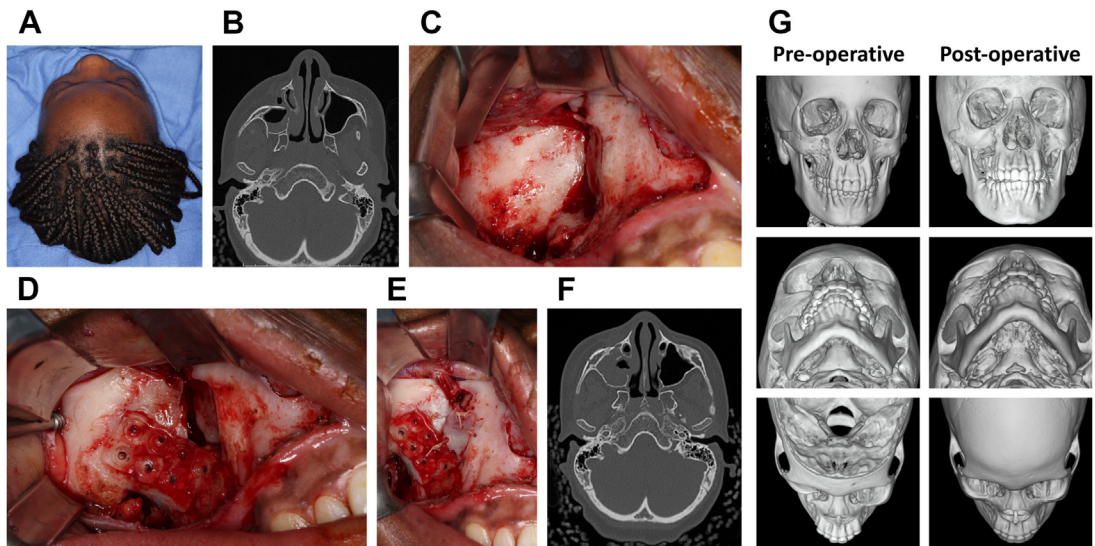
Case of a right ZMC fracture in a 12-year-old patient. (A) Bird's eye view showing deprediction of the right malar eminence. (B) CT axial view verifying depressed ZMC fracture. The fracture (C) exposed through a transoral approach, (D) reduced with a Carroll-Girard T-bar screw, and fixated with resorbable plating. (E) Unsupported anterior maxillary bone fragment replaced and secured with bone sutures. (F) CT axial view of final post-operative result showing restored malar projection. (G) Comparison of preoperative and postoperative 3-dimensional renderings on frontal, worm's-eye view, and bird's-eye view.
